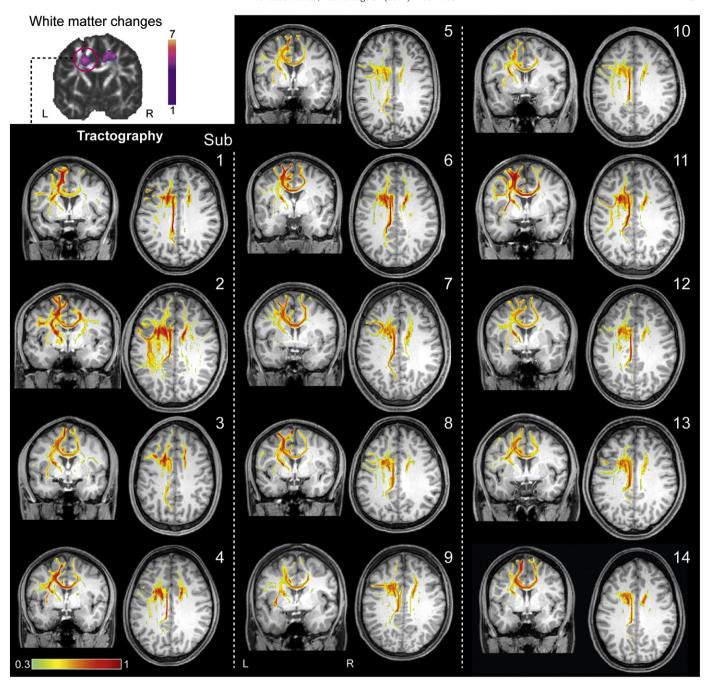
Probabilistic tractography from seed region in left anterior centrum semiovale. (a) Parametric (with individual performance values) mean diffusivity decrease in anterior centrum semiovale (mean diffusivity data from Taubert et al., 2010). (b) Individual maps from probabilistic tractography using left anterior centrum semiovale as a seed region (purple circle). Connectivity maps were overlaid on individual T1-weighted images. The bar was scaled according to the individual maximum probability value (value of 1) in each image. L, Left; R, Right.
